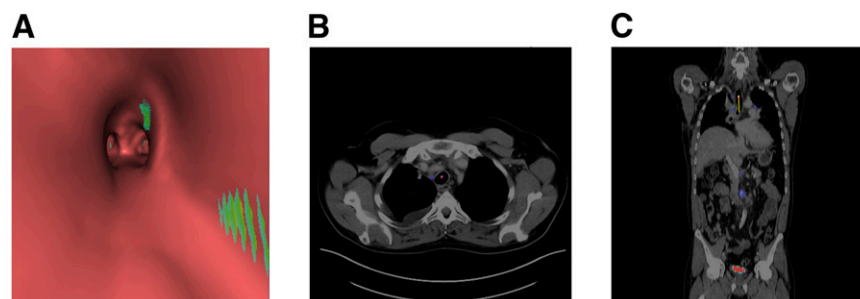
FP lesion with apparent focal PET uptake in positions 2R and 4R on virtual ^{18}F -FDG PET/CT bronchoscopy (A). On axial (B) and coronal (C) ^{18}F -FDG PET/CT, there was no corresponding lesion with elevated uptake was detectable.
